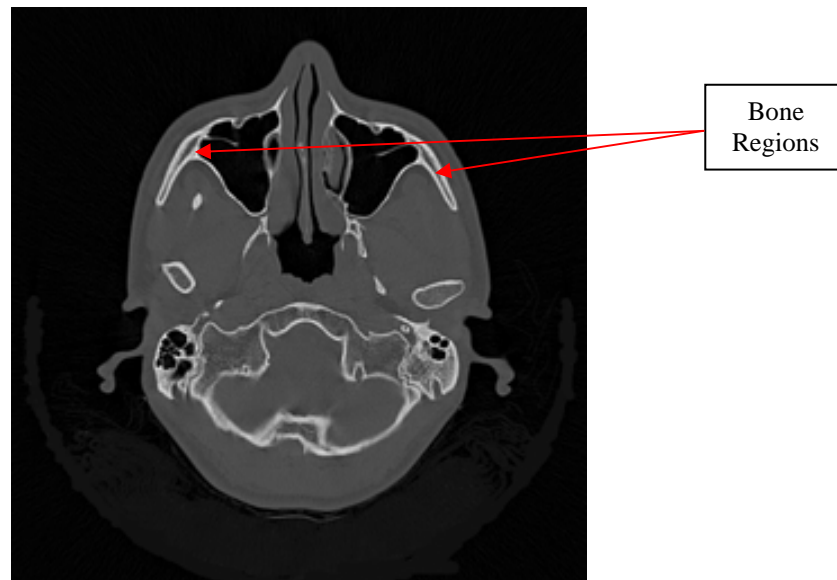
CT image with identified bone regions.
